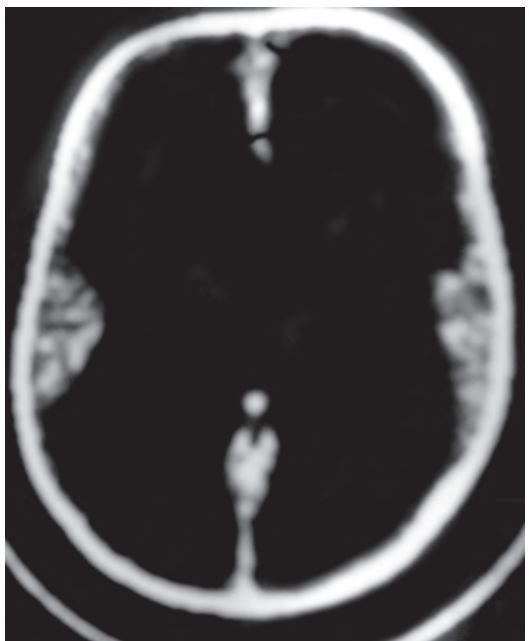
CT scan of the brain showing gross hydrocephalus
